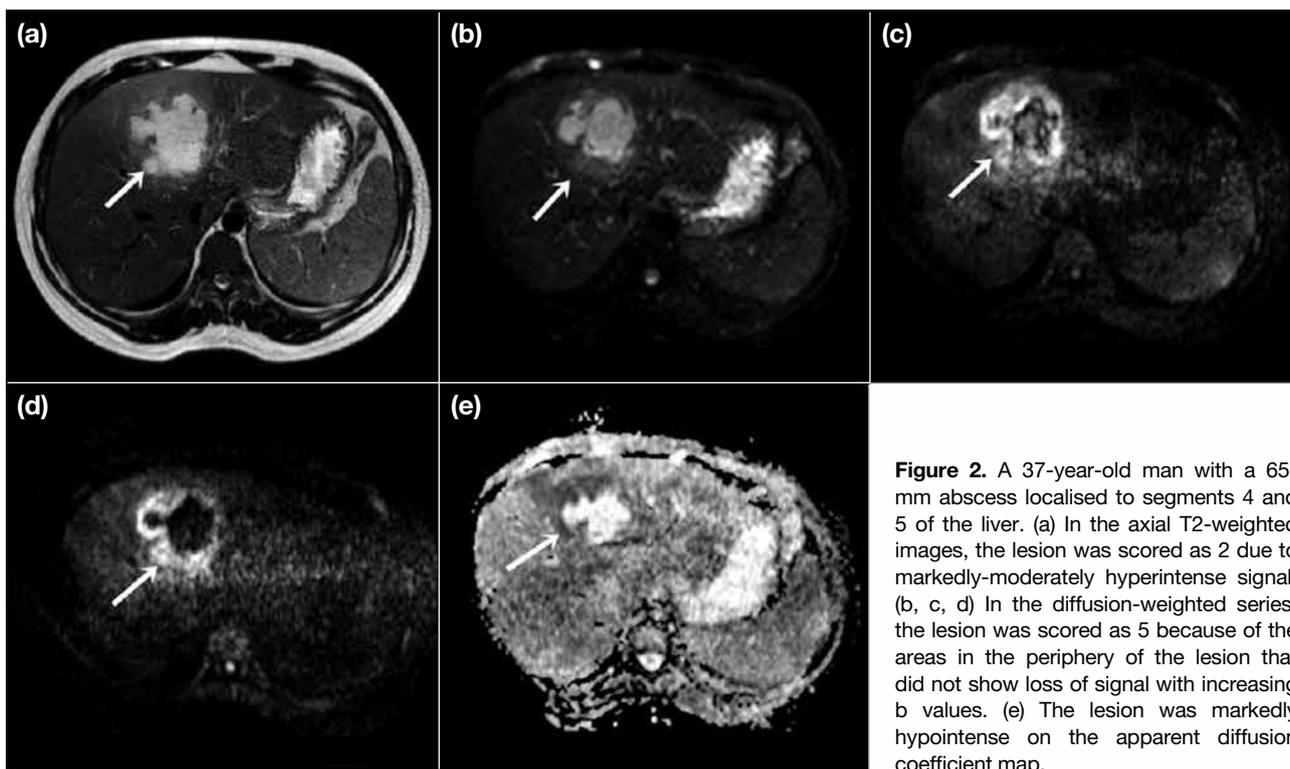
A 37-year-old man with a 65-mm abscess localised to segments 4 and 5 of the liver. (a) In the axial T2-weighted images, the lesion was scored as 2 due to markedly-moderately hyperintense signal. (b, c, d) In the diffusion-weighted series, the lesion was scored as 5 because of the areas in the periphery of the lesion that did not show loss of signal with increasing b values. (e) The lesion was markedly hypointense on the apparent diffusion coefficient map.
